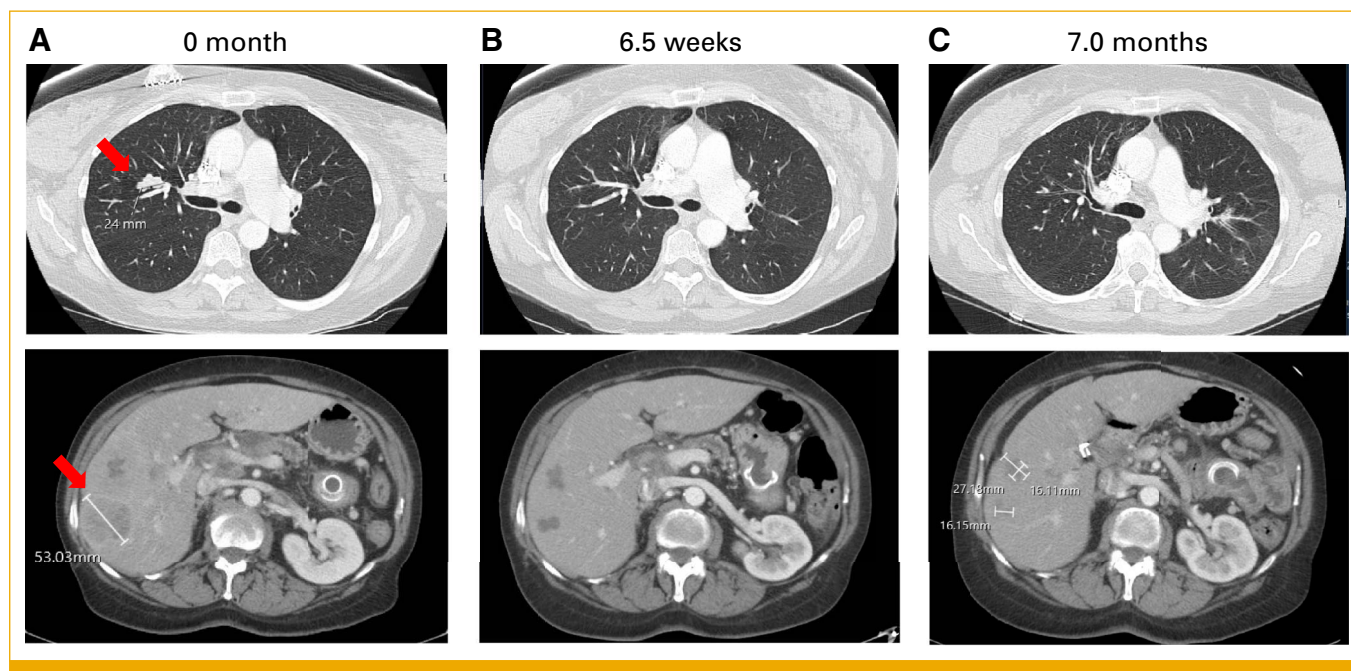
(A) Pretreatment CT of the chest and abdomen/pelvis. (B) CT of the chest and abdomen/pelvis after 6.5 weeks on repotrectinib shows resolution of pulmonary nodules and partial response of liver metastases. (C) CT of the chest and abdomen/pelvis after 7.0 months on repotrectinib shows partial response to therapy. CT, computed tomography.
